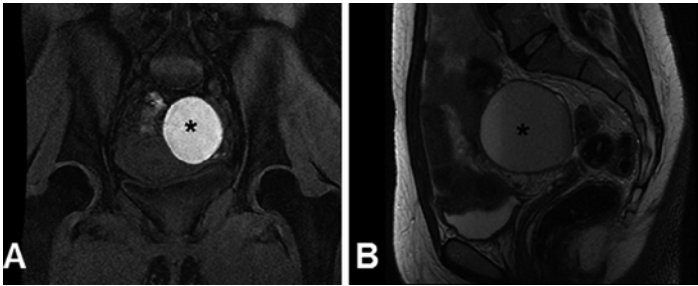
Endometrioma by MRI. (a) Left adnexal endometrioma, indicated with an *asterisk* (\*), by T1-weighted fat-suppressed MRI image. (b) Left adnexal endometrioma, indicated with an *asterisk* (\*), by T2-weighted MRI image
